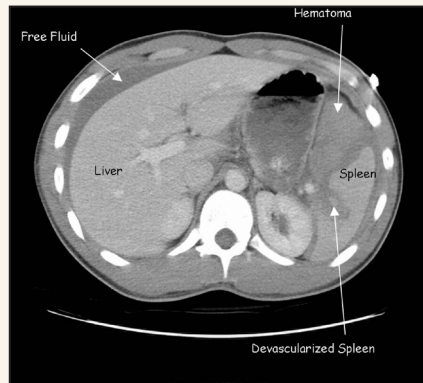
Enhanced CT scan of the abdomen showing laceration of the spleen and a large amount of perisplenic and free abdominal fluid compatible with hemorrhage.
